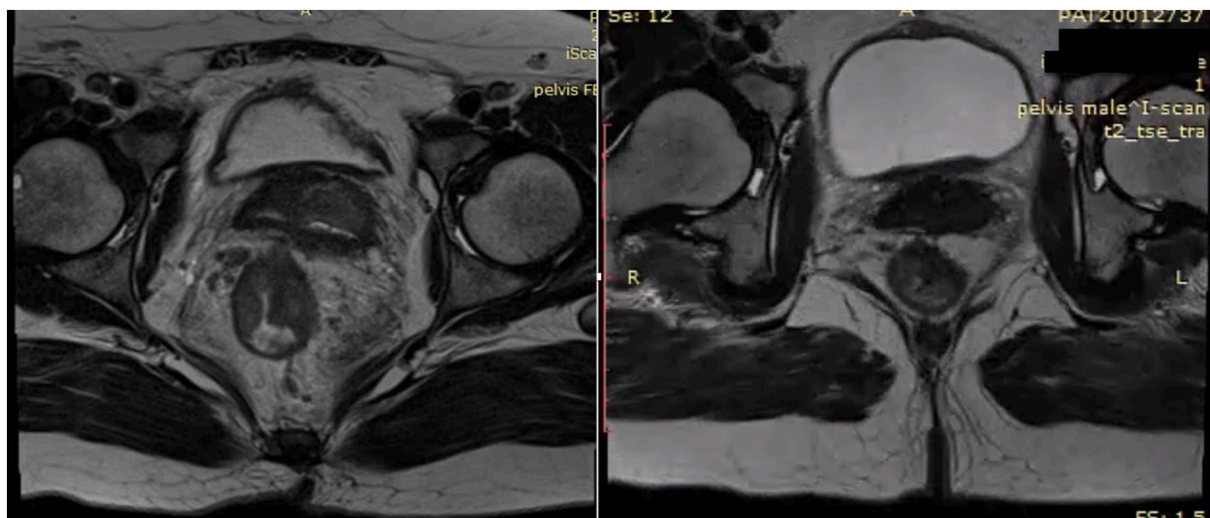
Magnetic resonance imaging of the pelvis with rectal protocol done pre-neoadjuvant and post-neoadjuvant therapy. (a) A circumferential intermediate signal intensity mid to low rectum on T2W abutting the mesorectal fascia anteriorly with no involvement of anal sphincters nor adjacent structures noted prior to neoadjuvant therapy. (b) Interval decrease in the size of tumor in the mid to low rectum with plane of cleavage to adjacent structures noted after neoadjuvant treatment.
